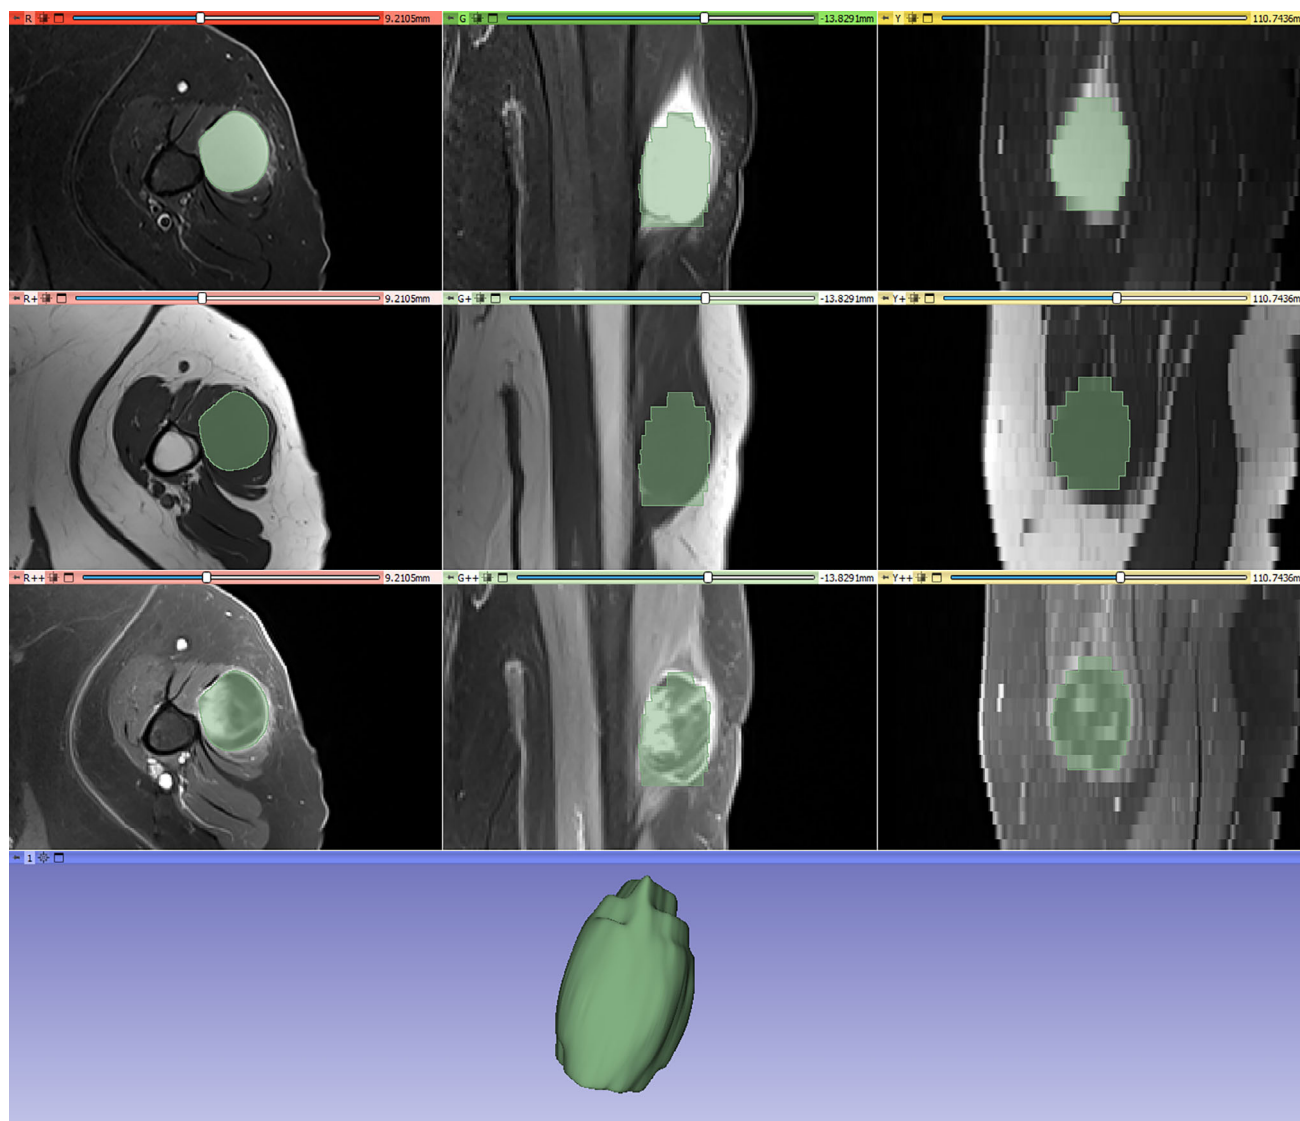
Manual segmentation process of a myxoma in 3D slicer using a custom view displaying T2-weighted fat-suppressed (top row), T1-weighted (middle row), and T1-weighted fat-suppressed contrast-enhanced (bottom row), in three planes. Segmentation (marked light green) was performed in the axial plane (left column). Corresponding coronal planes are shown in the middle column. Reformats of the axial slices are displayed (in this example in the sagittal plane, right column), when no original images in the corresponding orthogonal plane were available.
